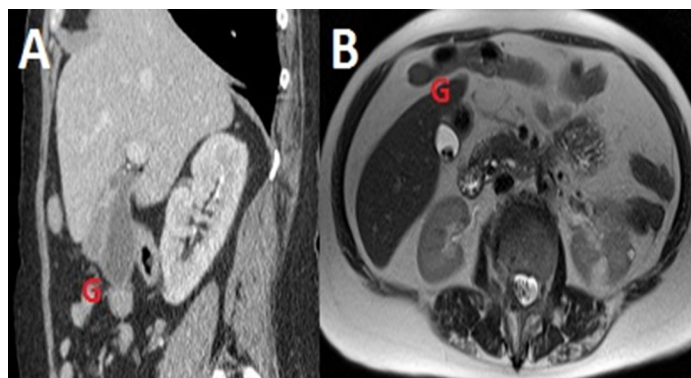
Image of the duplicated gallbladder on CT and MRI
